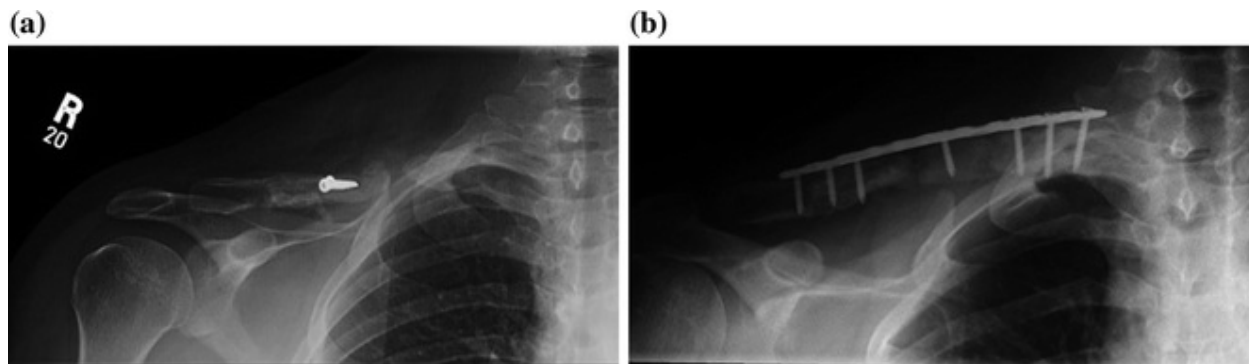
a Preoperative radiograph of midshaft clavicle nonunion in a 39-year-old man who had failed two prior attempts at operative fixation. There is significant bony defect. b Post-operative radiograph of midshaft clavicle nonunion following open reduction and internal fixation with a precontoured plate and an intercalary tricortical iliac crest bone graft
